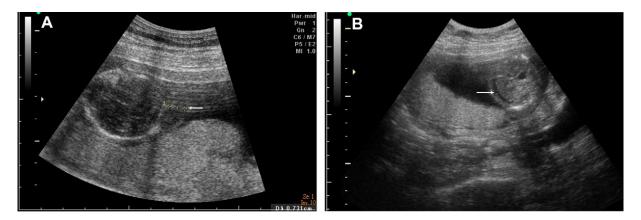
Prenatal ultrasound at 16 weeks of gestation shows (A) nuchal edema (arrow) and (B) mild fetal ascites (arrow).
